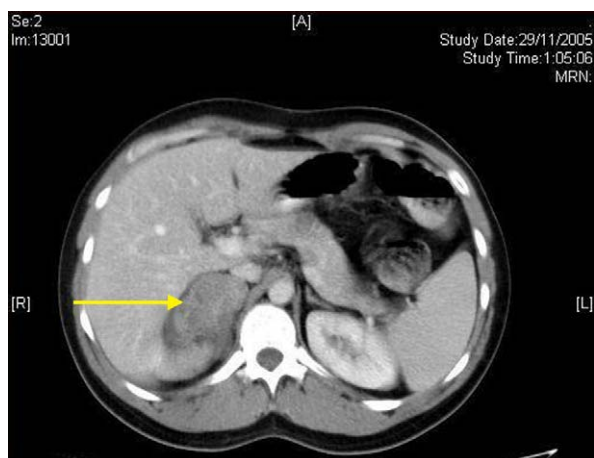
CT image showing a low attenuation oval solid mass in the right adrenal gland.
